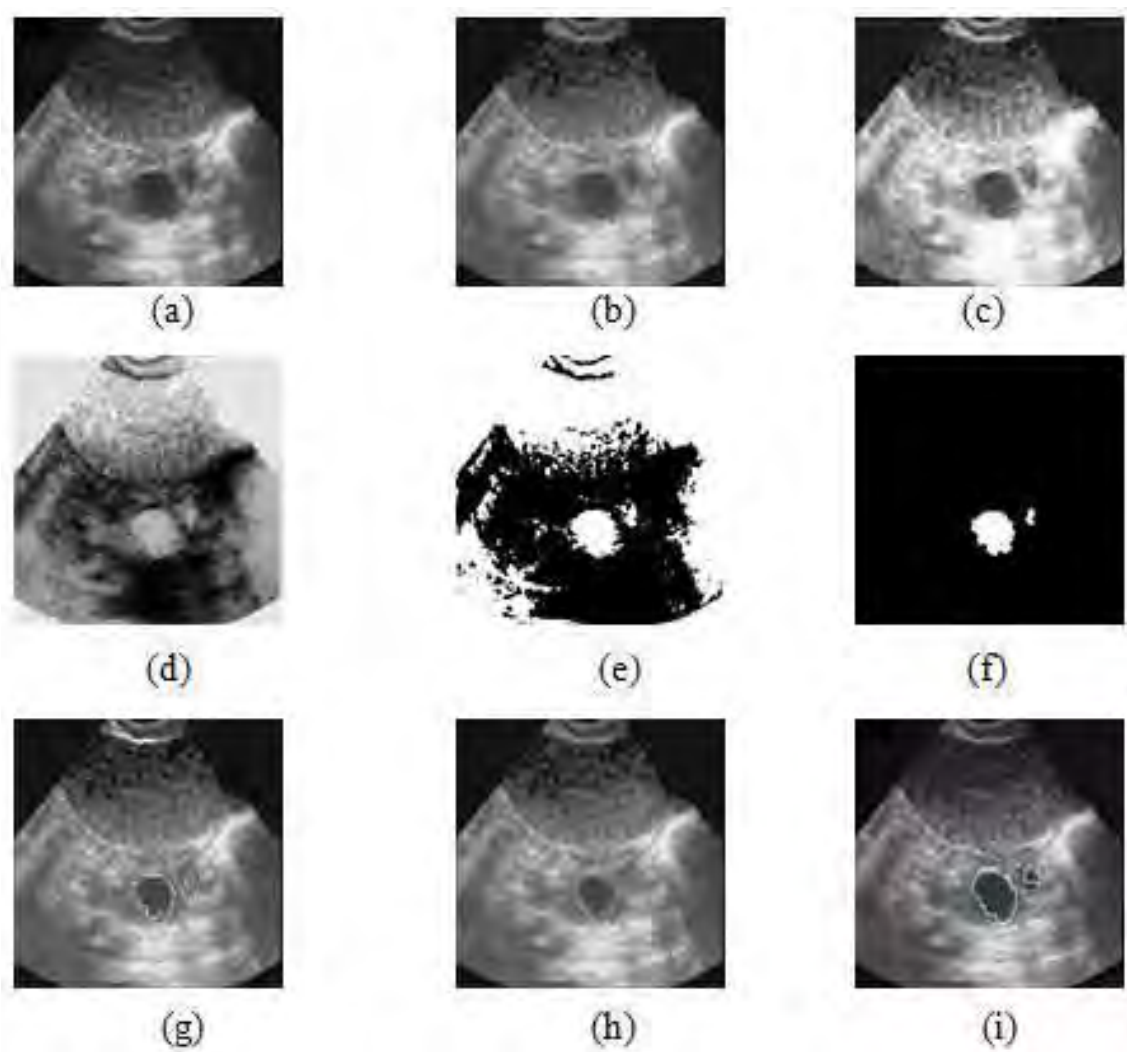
Original ultrasound image of the ovary and resultant images at different steps of proposed method. a) Original image, b) Contourlet transformed image (despeckling), c) Histogram equalized image, d) Image after applying negative transformation, e) Image after applying active contour without edges method, f) Segmented image after clearing the border, filling the holes and removing the small regions, g) Image showing recognized follicles (outlined in white) super imposed on the original image, h) Output image after classification, i) Manual segmentation of follicles by medical expert.
